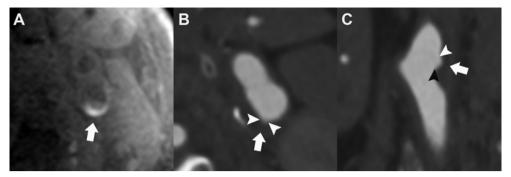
Correlated intraplaque hemorrhage on MR imaging and plaque ulceration on MDCTA. An example of MR imaging and MDCTA images of the left carotid bifurcation. On the 3D-T1W fat suppressed echo-spoiled gradient echo MR imaging sequence, intraplaque hemorrhage is visible in the atherosclerotic plaque (A, arrow). MDCTA images show a small ulceration on both the transversal and longitudinal plane at the site of the intraplaque hemorrhage (B and C, arrows; arrowheads indicate the edges of the plaque ulceration).
